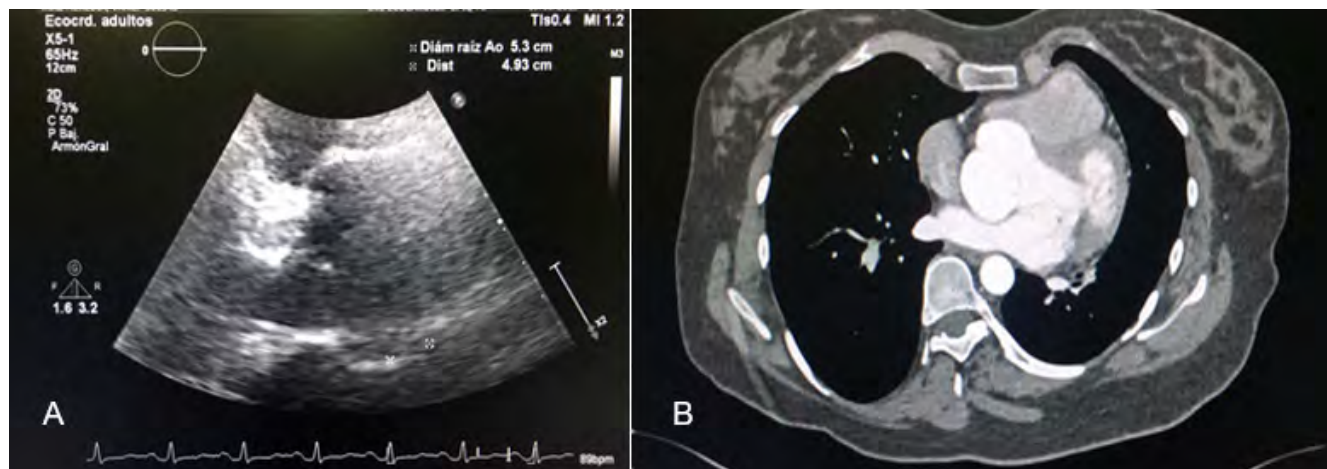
A) Echocardiogram showing jet of aortic regurgitation, B) Angiotomography showing significant aneurysmal dilation of the valsalva sinuses.
